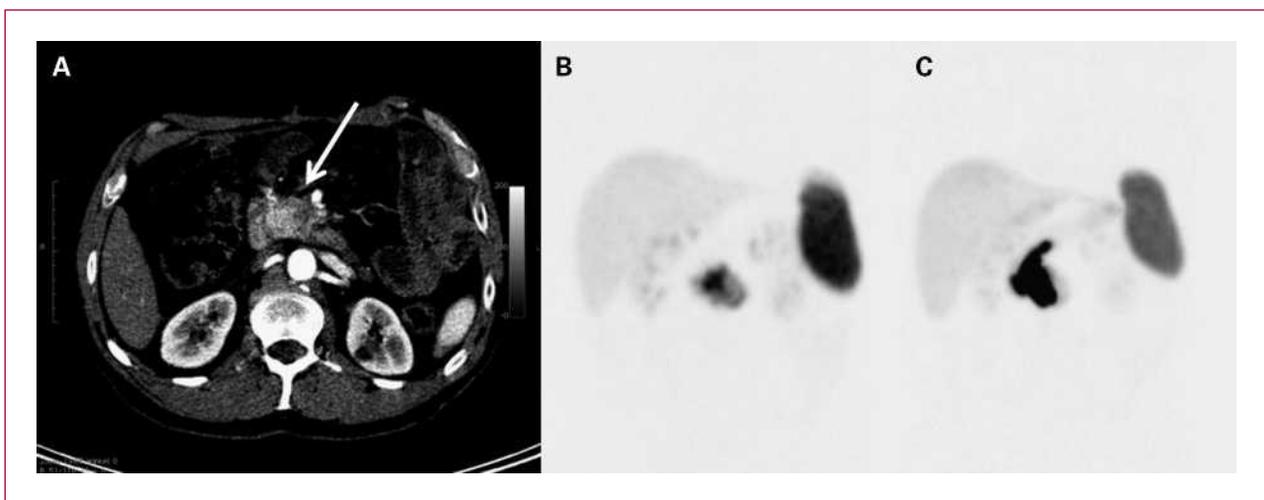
Patient with neuroendocrine cancer in the mesenteric root (P-NET) shown by contrast-enhanced CT (arrow, tumor lesion). After selective exploration of the gastroduodenal artery, tumor uptake was enhanced 7.8-fold (SUV 279.4 versus 35.7) after i.a. (C) in comparison with i.v. (B) injection of ^{68}Ga -DOTATOC.
